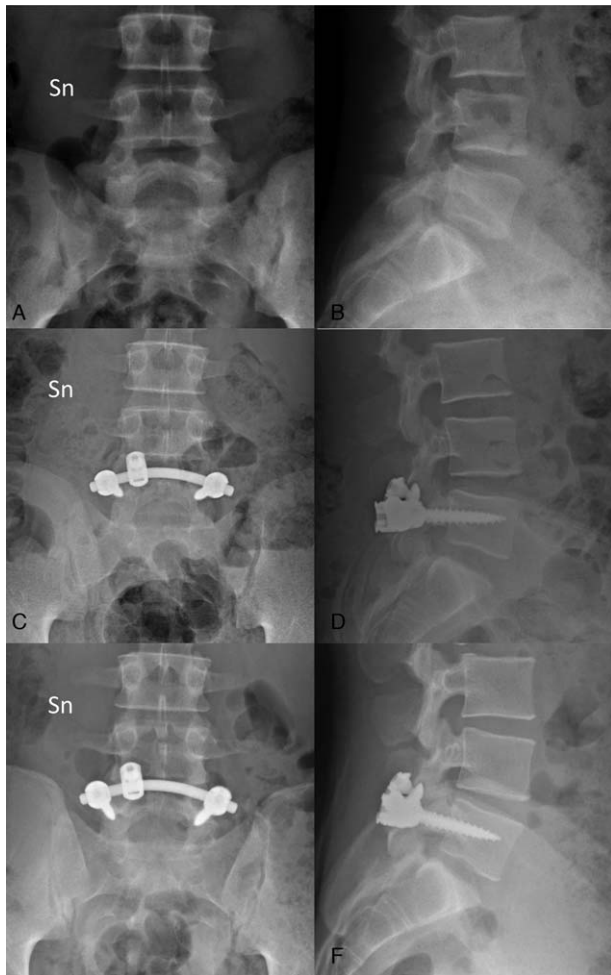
Case example. Screw-Rod-Band (SRB) Technique. Preoperative coronal (A) and Sagittal (B) x-ray. Postoperative coronal (C), and sagittal (D) x-ray. X-ray, 4 years follow-up (E) coronal and sagittal (F).
